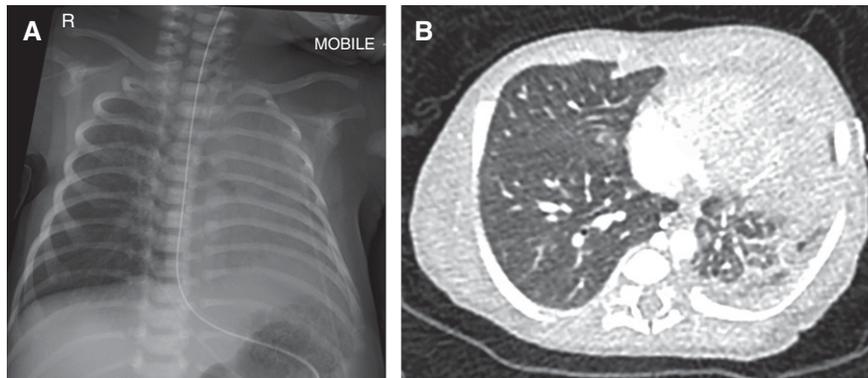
(A) Chest radiograph (Day 5 of life). (B) Computed tomography image at the level of electrical impedance tomography imaging (performed Day 8 of life).
